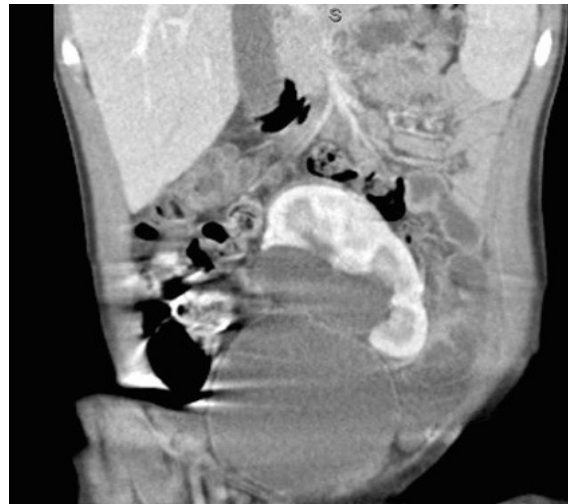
Computed Tomography of the Abdomen - Interpreted as left pelvic kidney with severe pelvicalectasis.
